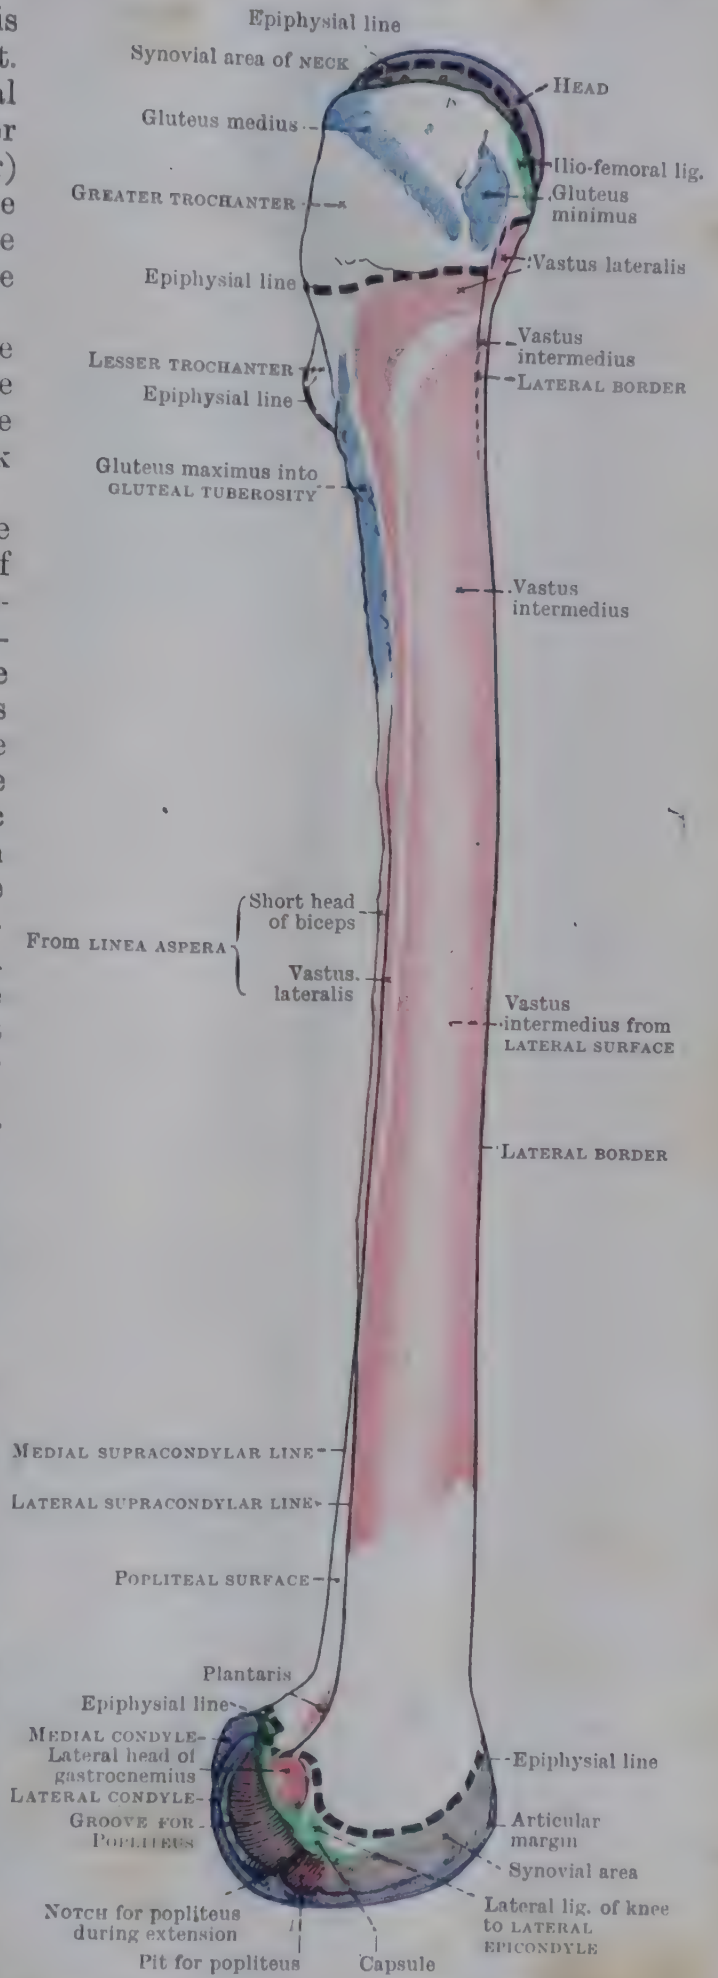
LATERAL ASPECT OF RIGHT FEMUR.
